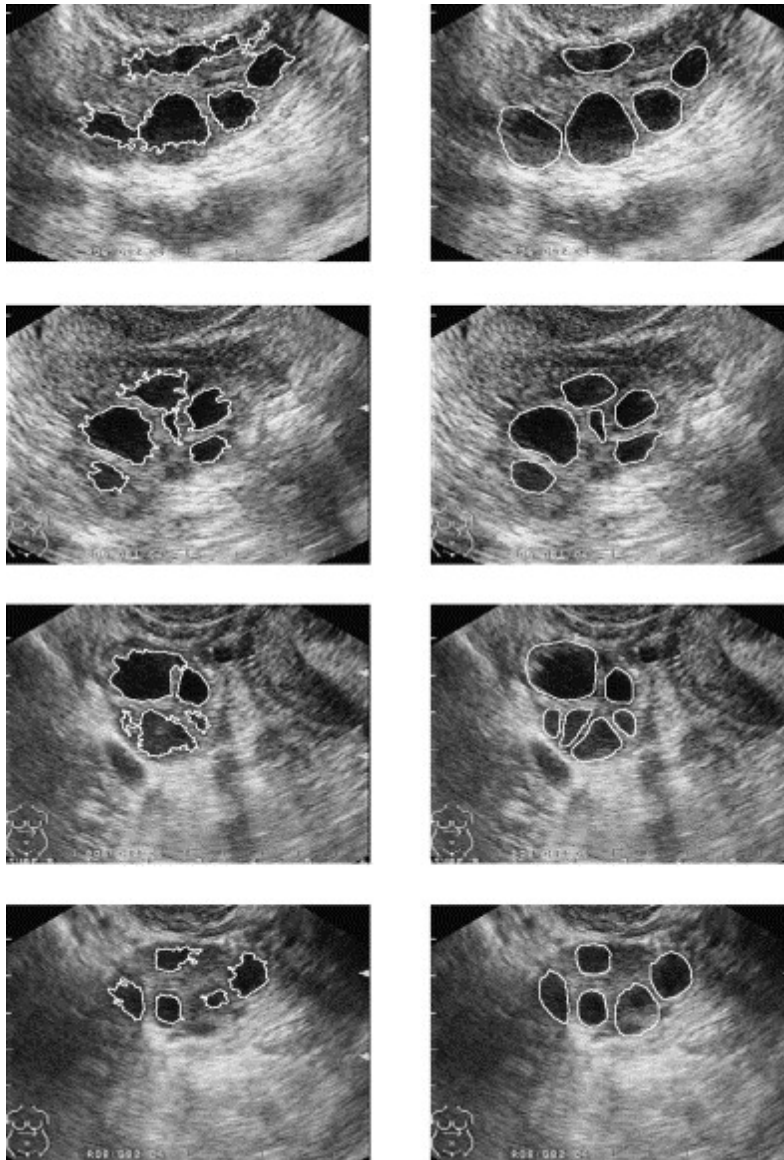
Example ultrasound images of ovarian follicles. Left column: follicles segmented by a computer algorithm. Right column: manual segmentation of follicles. Figure taken with permission from [73].
